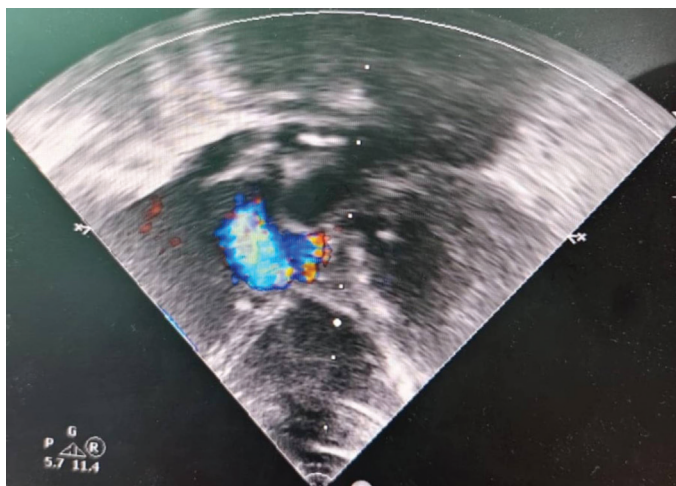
Preoperative echocardiography demonstrating pulmonary atresia with intact ventricular septum, secundum atrial septal defect with bidirectional shunt, patent ductus arteriosus, hypoplastic pulmonary arteries, right-sided chamber dilation with moderate tricuspid regurgitation and preserved left ventricular systolic function
